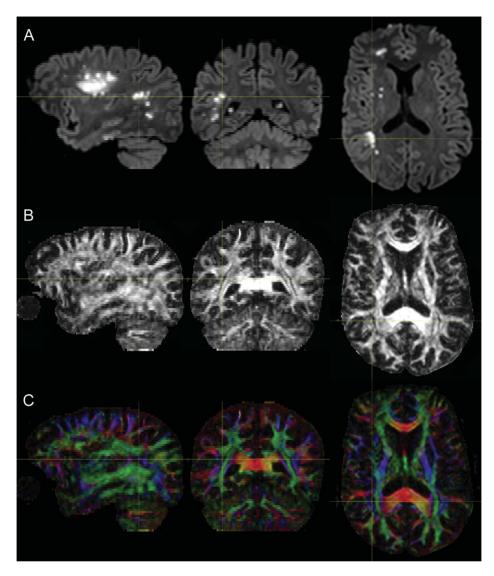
Axial diffusion-weighted MR images (A) in three orthogonal planes showing hyperintense signal abnormalities in the right subcortical white matter at the TPJ. Fractionary anisotropy maps (B) show decreased anisotropy in the lesion (FA=0.496 on the right, FA=0.535 on the contralateral side). Orientation color maps (C) confirmed that the lesion is involving a portion of the tract (colored in blue) along the AF. Note that there was no evidence of cortical ischemic infarcts on DWI at 60 hours after symptoms onset.
